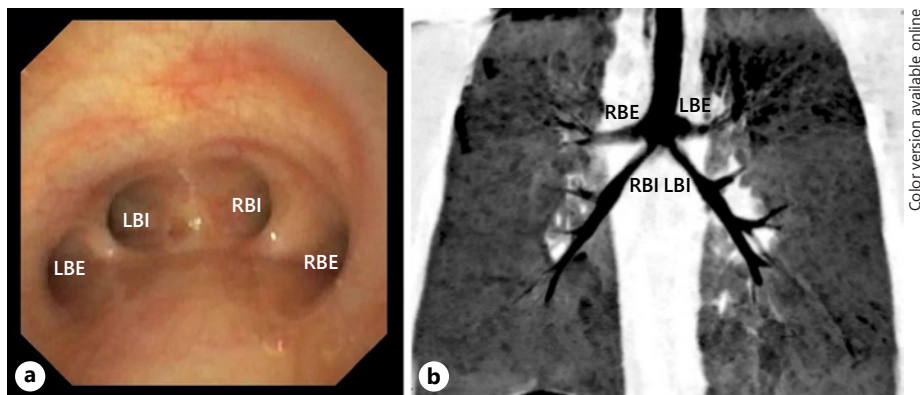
Endoscopic (a) and CT images with labelled bronchi (b).
